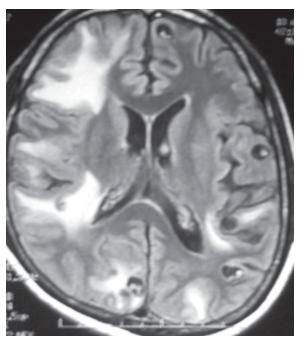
MR imaging showing multiple viable cysts with perifocal edema. Lesions are also showing eccentric scolices
